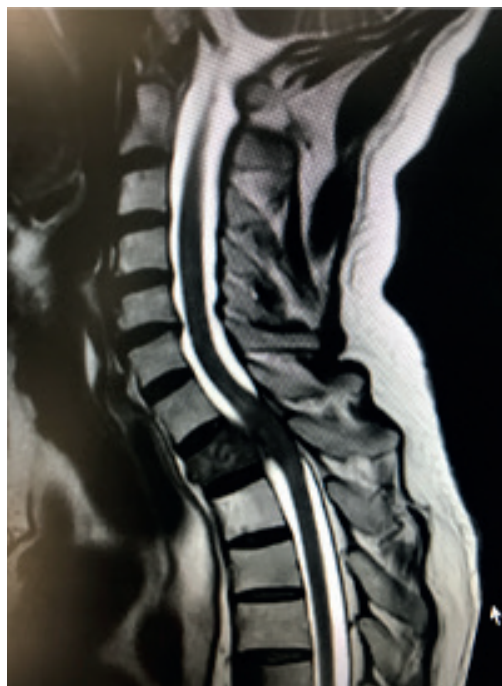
MRI T2 weighted sagittal image of cervical and upper thoracic spine showing T1 vertebral body metastases with epidural extension causing compression of spinal cord.
